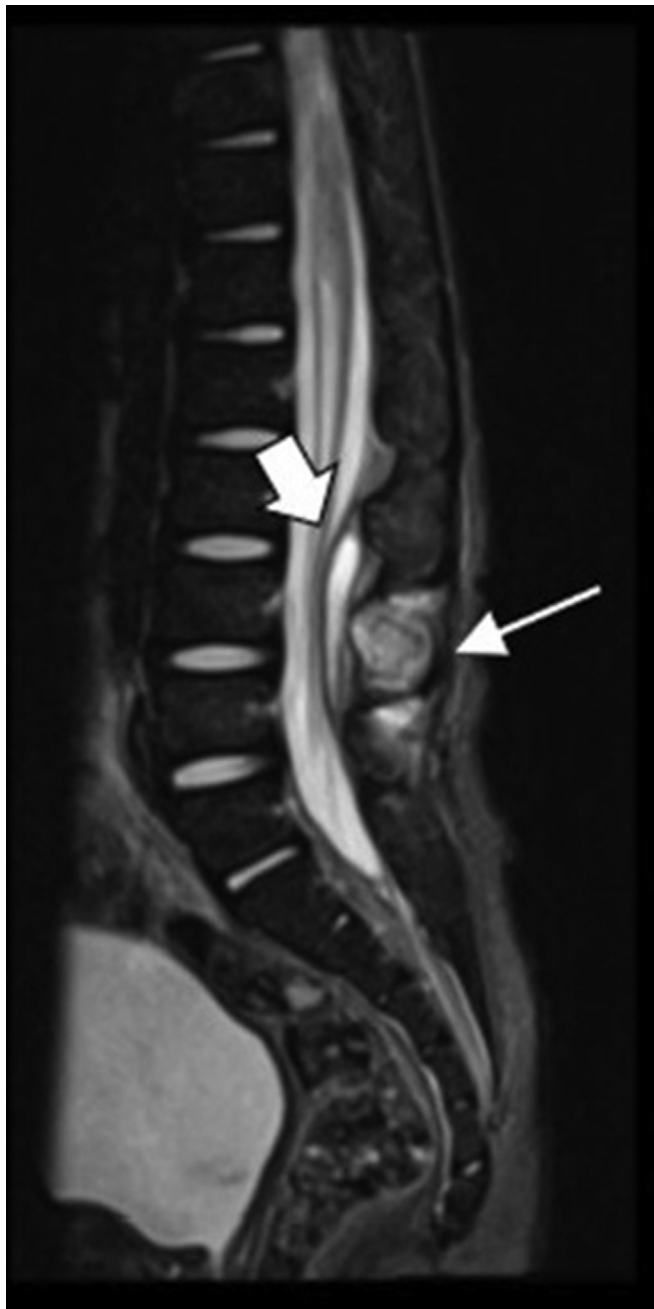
MRI of the lumbar spine, sagittal T2-weighted image of a young male patient with acute low back pain. There is high T2 signal of posterior vertebral elements at the low lumbar levels, with slight expansion (arrows) and associated epidural fluid collection (open arrow). Unfortunately, due to technical limitations, it was not possible to obtain post-gadolinium T1-weighted or DWI images, which would facilitate the diagnosis. Even though the patient had increased inflammatory parameters and fever, favouring osteomyelitis with associated epidural abscess/empyema, the patient underwent surgery and this diagnosis was confirmed.
